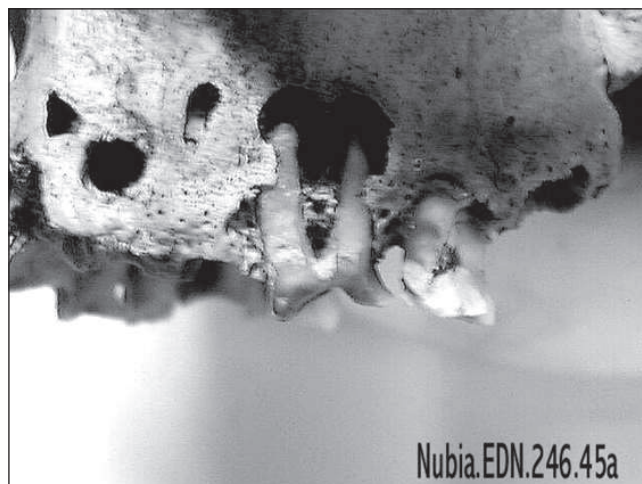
The extreme wear of the upper left 1st molar has caused a bony lesion suggestive of periapical infection.
